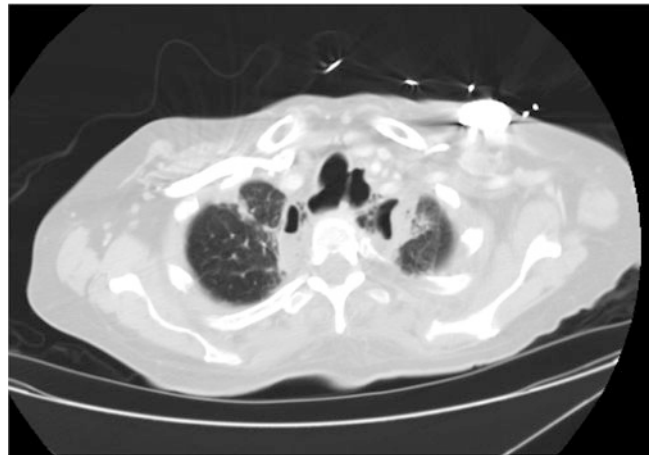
Computed tomography (CT) scan of a tracheo-esophageal fistula after chemotherapy and radiation therapy for esophageal squamous cell carcinoma
